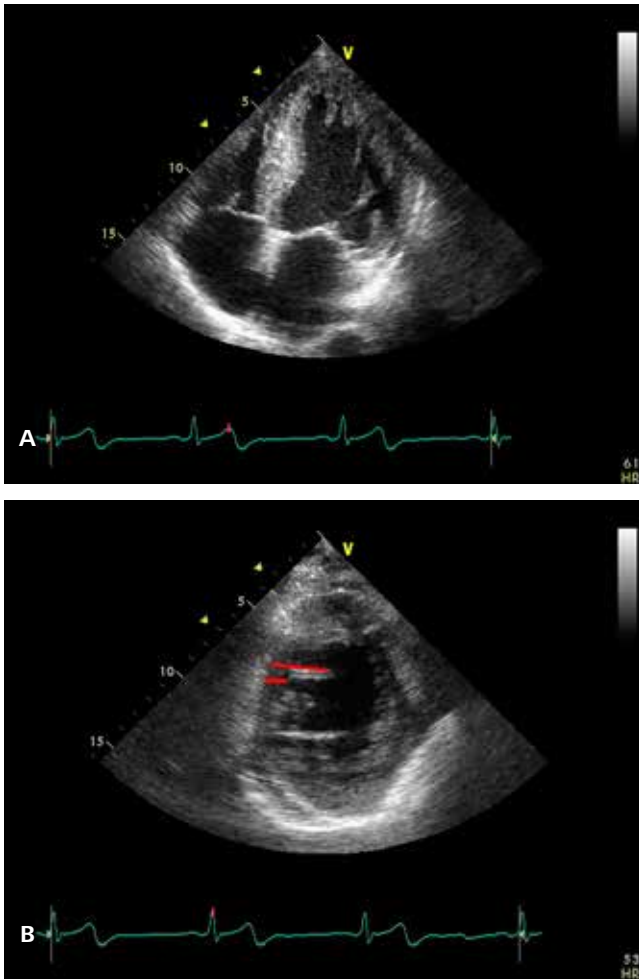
Transthoracic echocardiography demonstrating intertrabecular recesses and trabeculations in the left ventricle. The flow in the trabeculations can be verified by the color Doppler method. The quotient of maximal compact wall to the total wall thickness was 0,38 ($\leq 0,5$)
